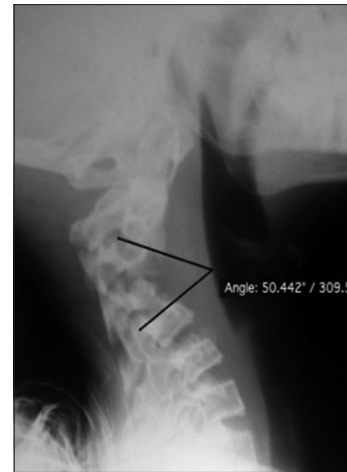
Traction X-ray at 9 kg of traction
